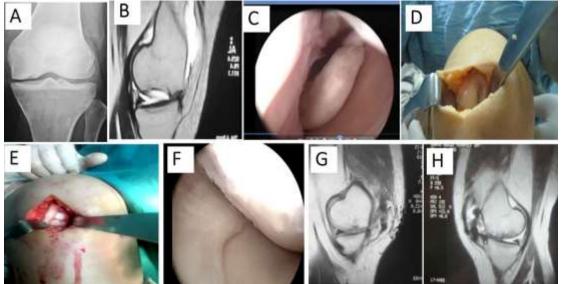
A 29 ys old female patient, with a symptomatic traumatic osteochondral defect in MFC, with a preoperative Lysholm score of 30 points. (A,B) Preoperative plain X-ray and MRI. (C): Arthroscopic view of a loose body in the lateral gutter. (D,E): Mini-arthrotomy approach showing the defect and the repair. (F): A secondry look arthroscopy done seven months-postoperatively [for arthrolysis of joint stiffness] showing integration of the graft. (G,H): Final MRI showing defect healing and good integratation of the grafts. At the last follow-up visit 18 months postoperatively; she regained 30° from lost ROM, the lysholm score was 66 points, the overall result was fair and the patient was unsatisfied.
